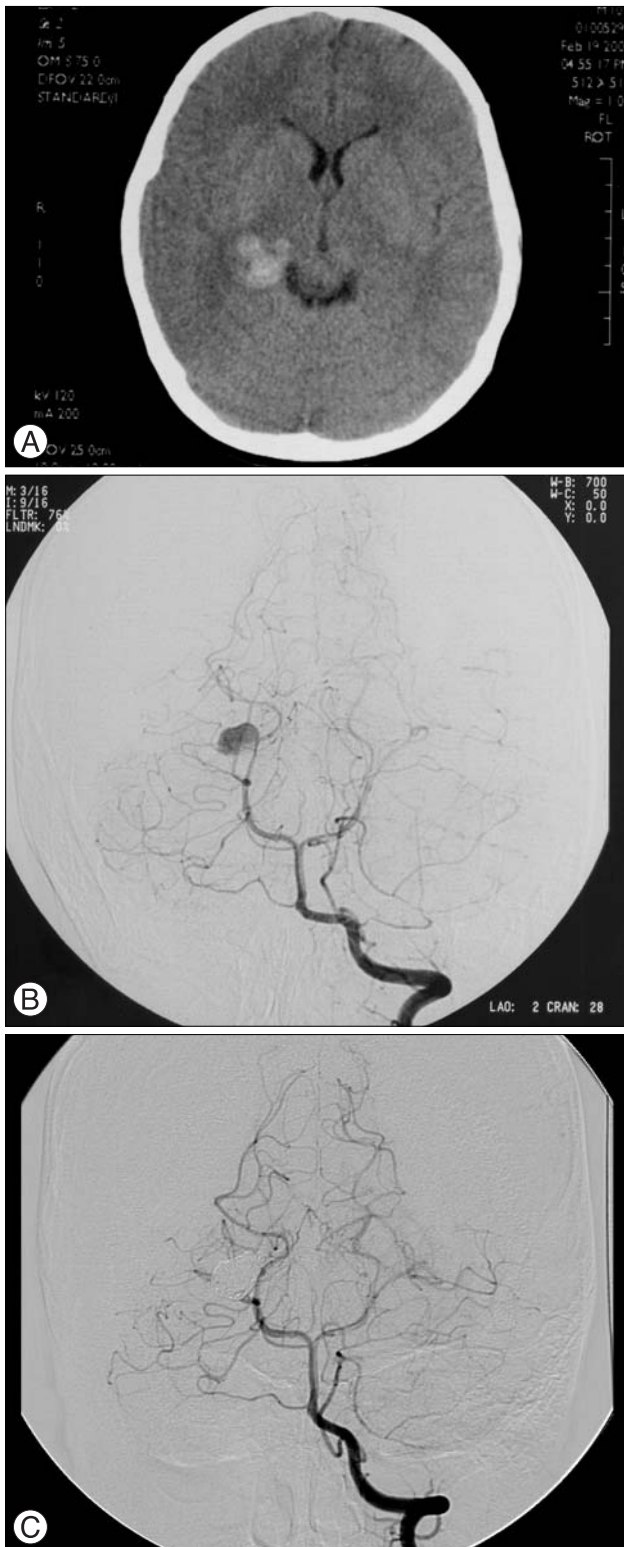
In Case 7, 11 years old boy presented with severe headache, vomiting. A : Brain computed tomography scan revealed intracerebral hemorrhage on right thalamus. B : Vertebral angiogram revealed large aneurysm at right P3–4 junction. C : Postembolization vertebral angiogram revealed complete obliteration of aneurysm.
